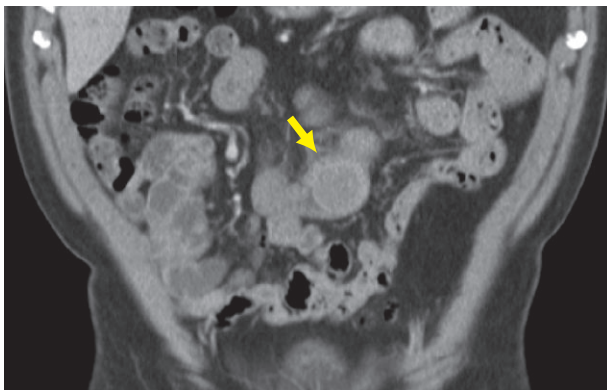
CT of a different patient shows intussusceptions secondary to a small bowel mass (arrow) in an adult patient.
